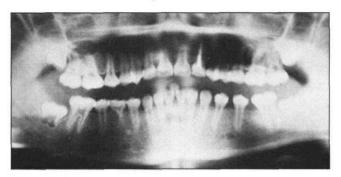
Panoramic radiograph demonstrating incomplete transposition of mandibular right premolar.
